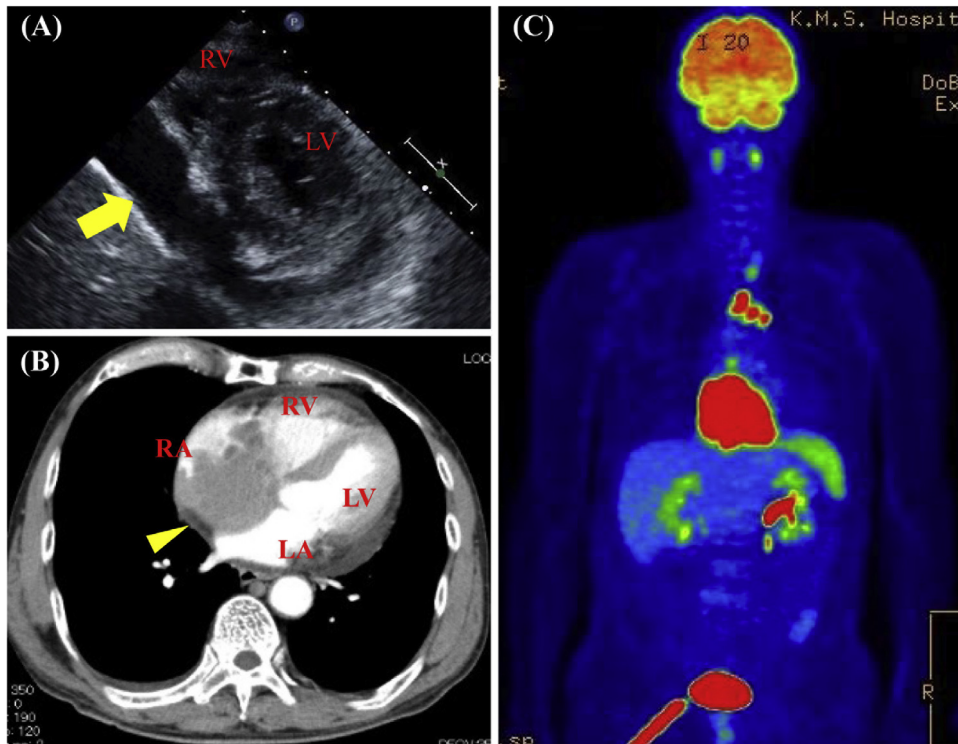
Preoperative images. (A) Preoperative transthoracic echocardiogram, pericardial effusion (arrow) and collapsed right ventricle are shown. (B) Preoperative computed tomograms showing a large heterogeneous mass (arrow head) involving the right atrium (RA). (C) High uptake of fluorodeoxyglucose (FDG) in the RA, RV, and mediastinal lymph node on FDG-position emission tomography. LA, left atrium; LV, left ventricle; RV, right ventricle.
